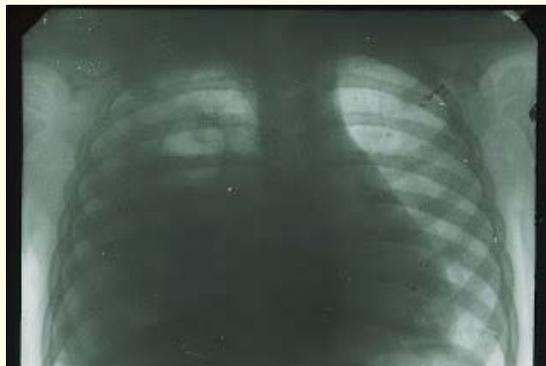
X-ray photograph of the same patient (see Figure 1), 36 hours after starting the inpatient care (antibiotic therapy, intravenous infusion therapy with detoxification). There is an intensive homogenous shading of almost the whole right hemithorax with mediastinum, dislocation to the left, and a cavity with a fluid level in upper pulmonary field. (Bacteriological examination of pus from the pleural cavity revealed no microflora).
